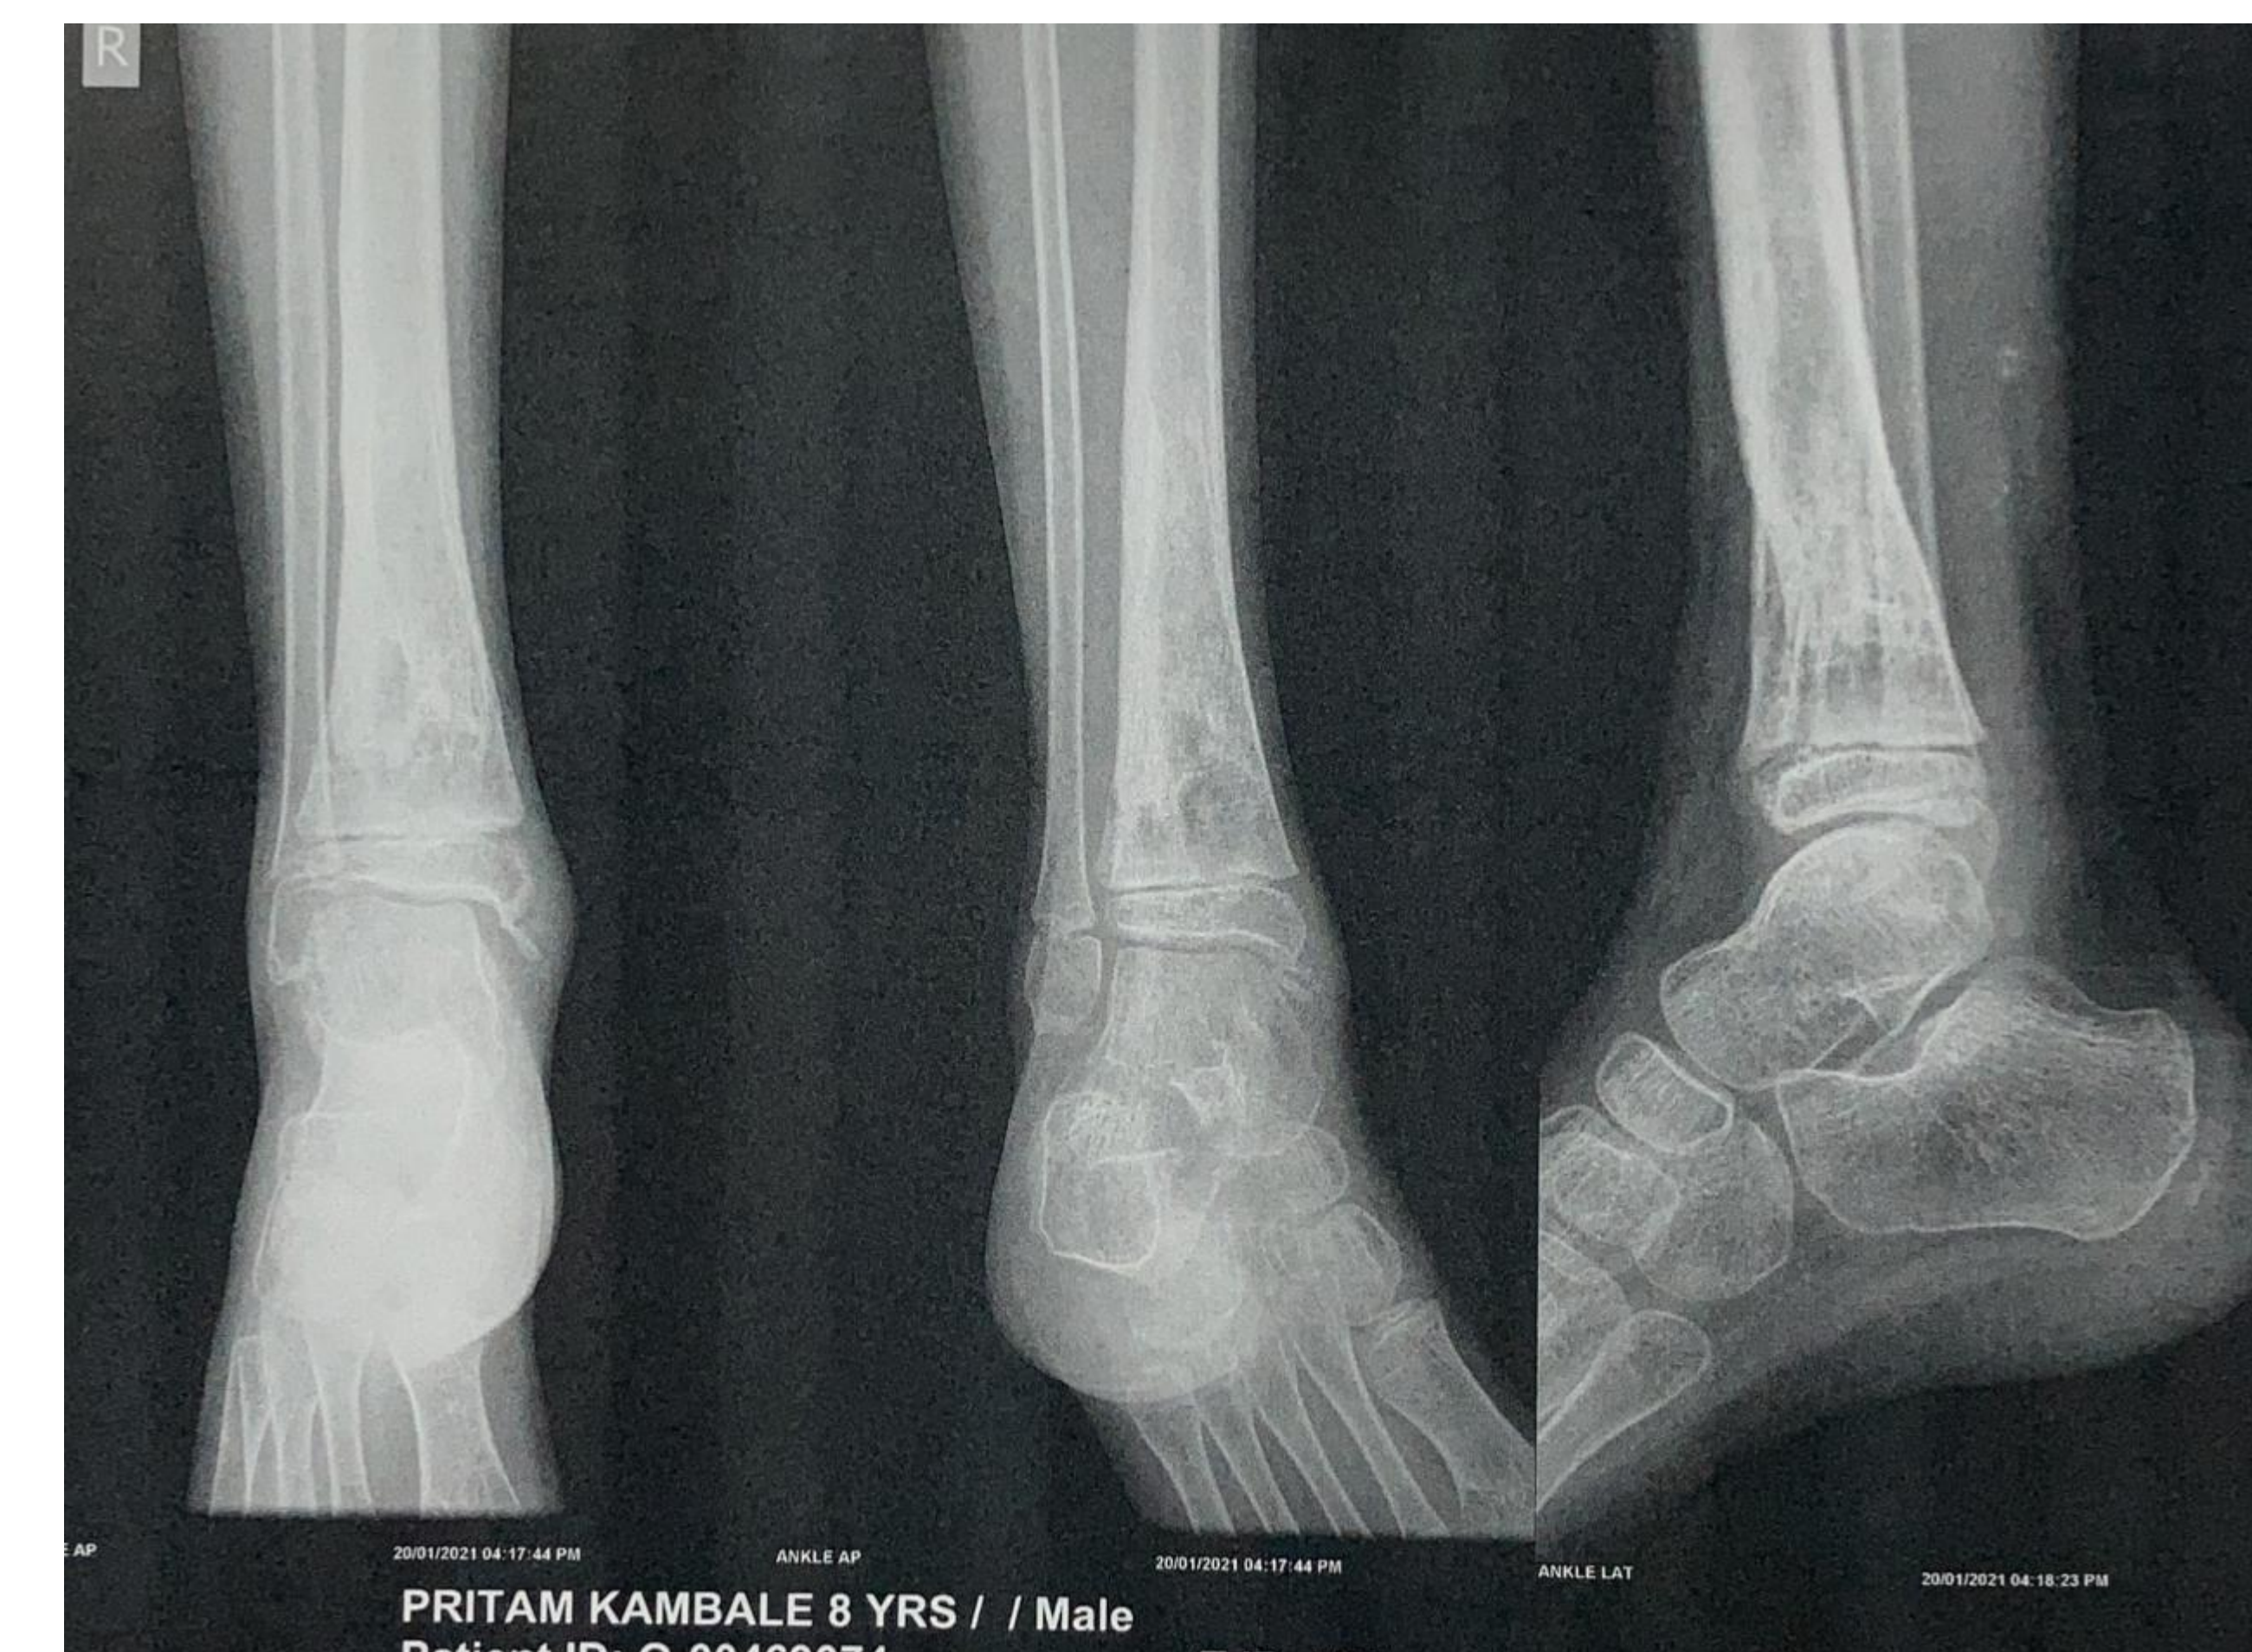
Final Post OP follow up Xray at 6 months
